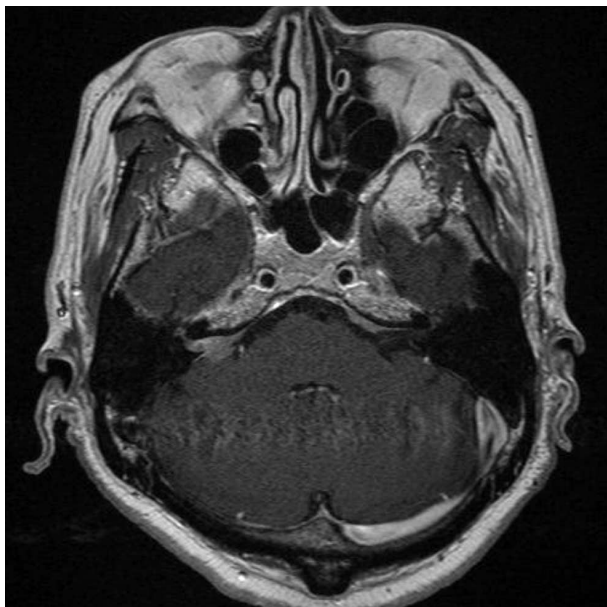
Gadolinium-enhanced T1-weighted axial MRI scan showing a space-occupying lesion involving right IAC and cisternal segment with dural thickening.
